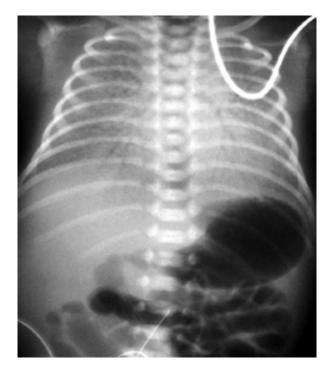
Chest X-ray showing classic air bronchogram sign
